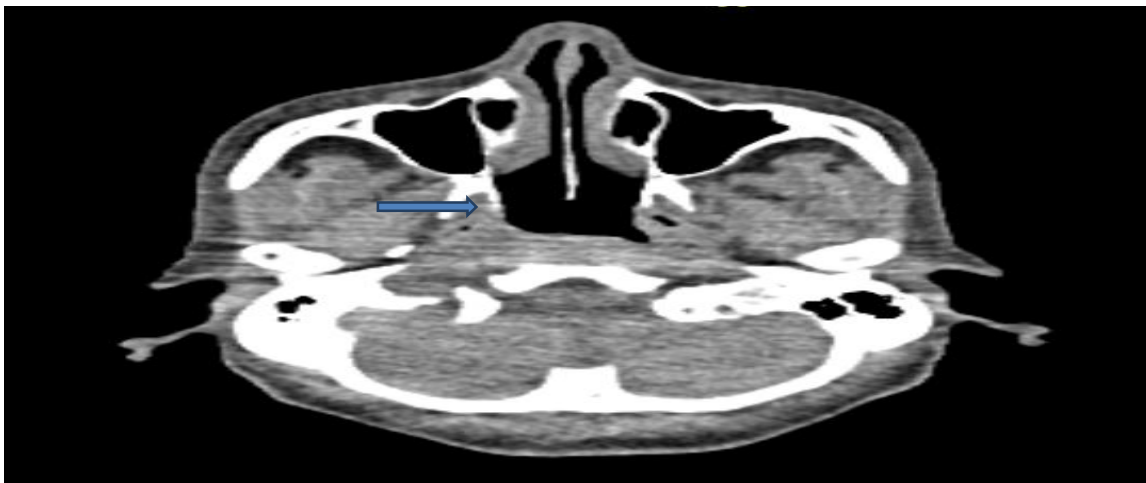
Computed tomography scan of paranasal sinus showed mass in right nasopharyngeal area with obliteration of FOR and eustachian tube as pointed by blue arrow
